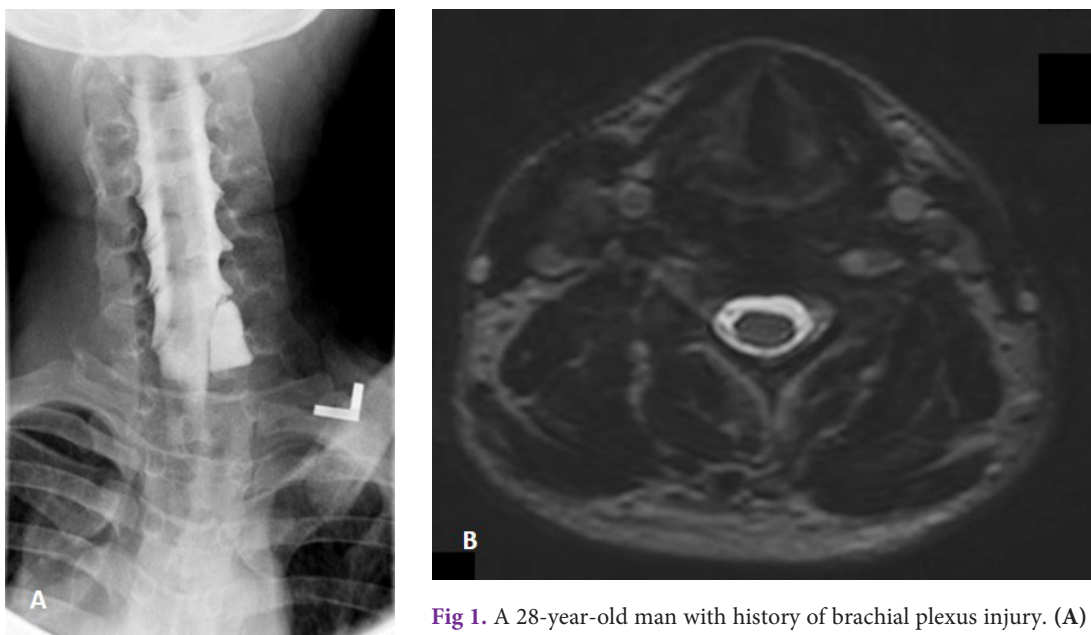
A 28-year-old man with history of brachial plexus injury. (A) Conventional myelography reveals no demonstration of normal left C5-T1 preganglionic nerve roots with pseudomeningocele at left C8 nerve root. (B) T2-weighted image-high resolution, no detectable normal ventral and dorsal left C5 nerve roots, representing nerve root avulsion.
